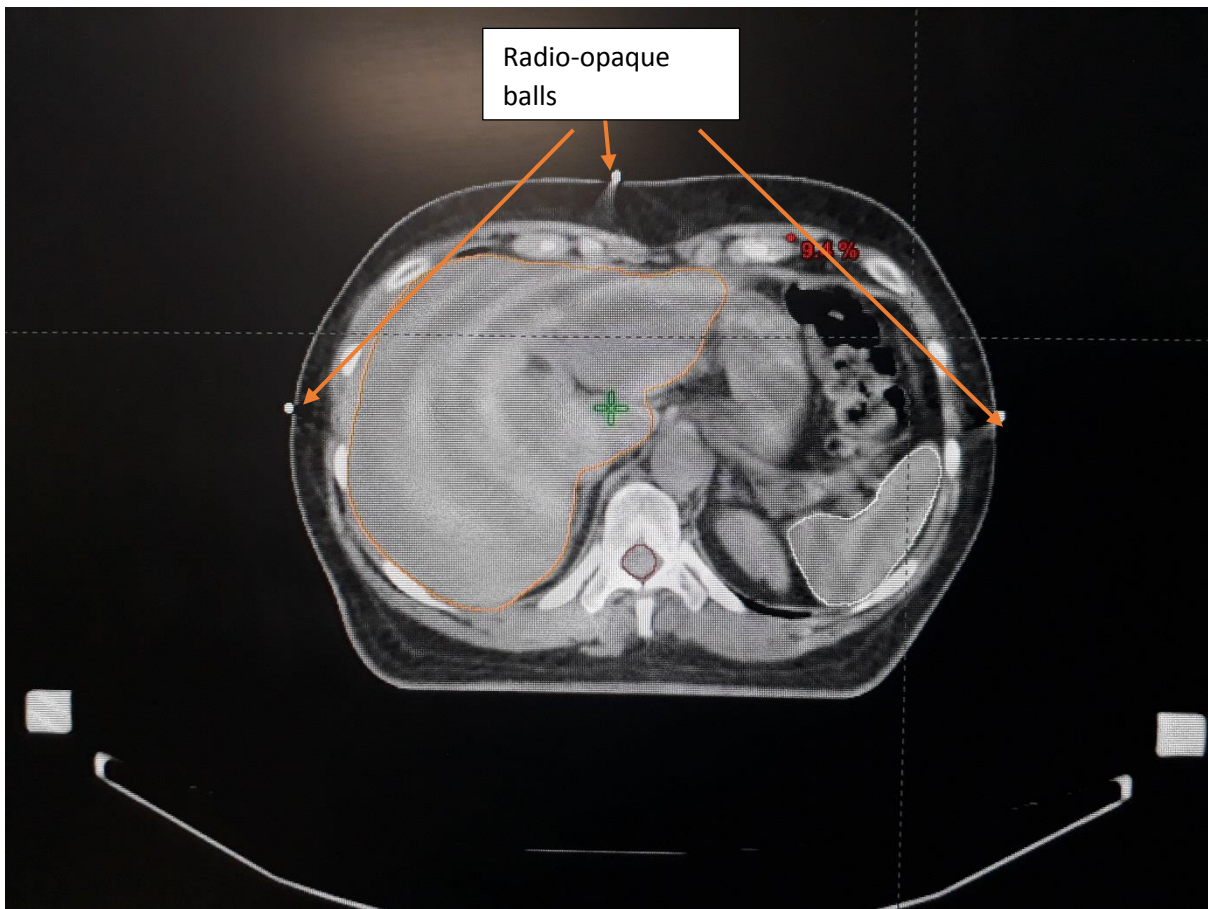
Axial CT slice with three opaque balls placed on the patient's skin.
